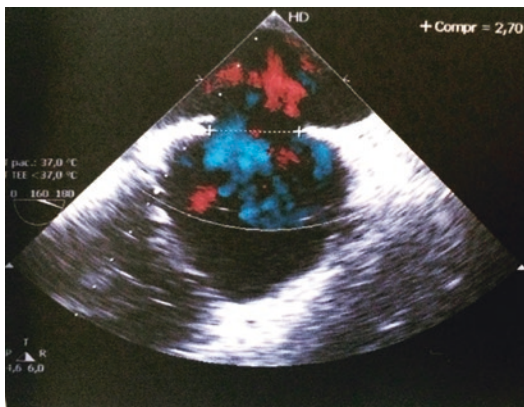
Echocardiography revealing atrial septal defect with a big left-to-right flow
